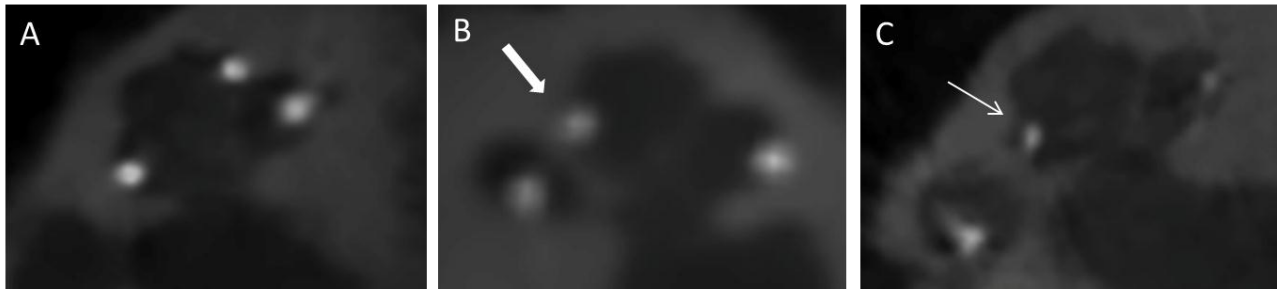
Cone beam CT in cochlear implanted patients. In A, all raters indicated the three electrodes in scala tympani position. The apical electrode in B (thick arrow) was indicated by all raters as translocated. In C the apical electrode (thin arrow) was considered in intermediate position by two raters and translocated by one, and finally considered as a traumatic insertion after consensus.
